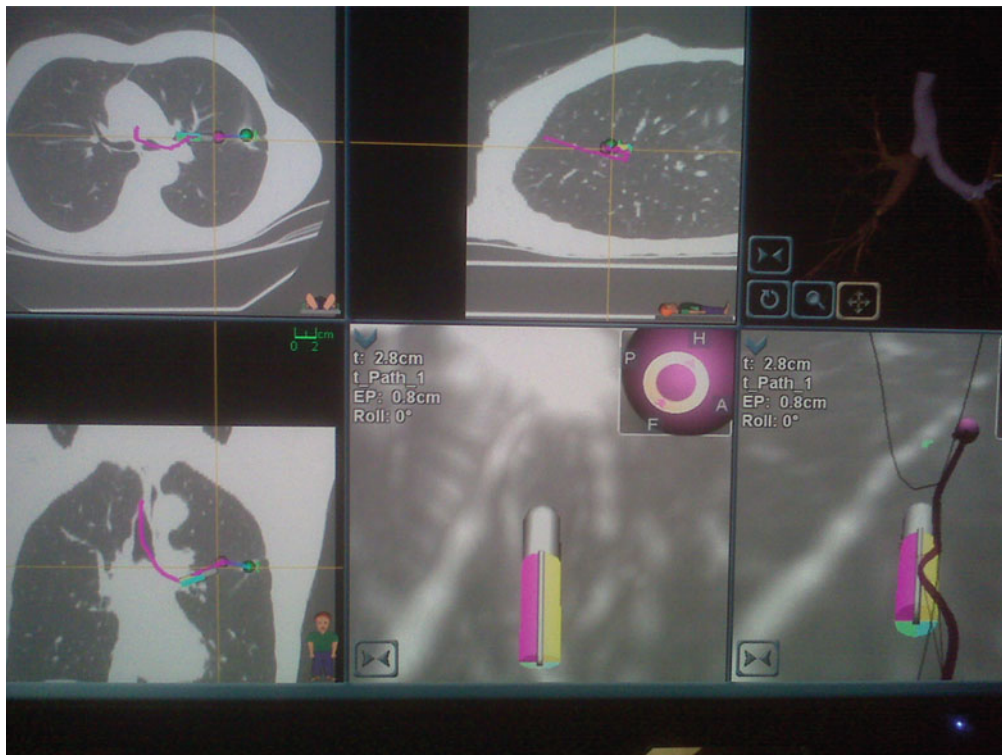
Sagittal, coronal, and transverse CT cuts showing locator guide and target. Local view and tip view of the locator guide (*bottom mid* and *right*, respectively)
